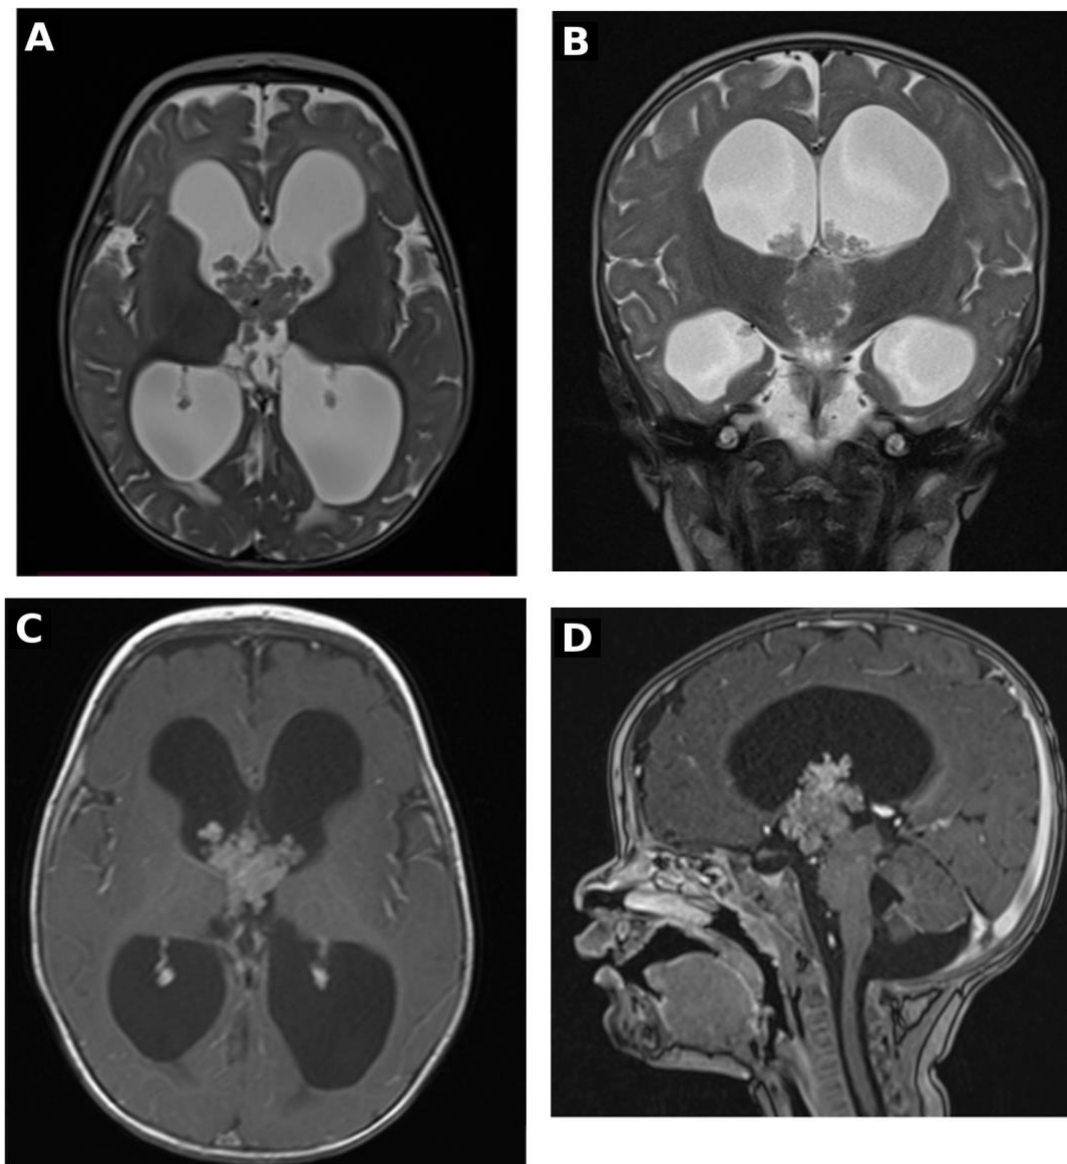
Magnetic resonance imaging of the third-ventricular mass. Axial (A) and coronal (B) T2-weighted images show a lobulated intraventricular mass centered on the third ventricle, associated with marked supratentorial ventriculomegaly. Axial (C) and sagittal (D) post-gadolinium T1-weighted images demonstrate avid heterogeneous enhancement and a papillary, frond-like configuration.
